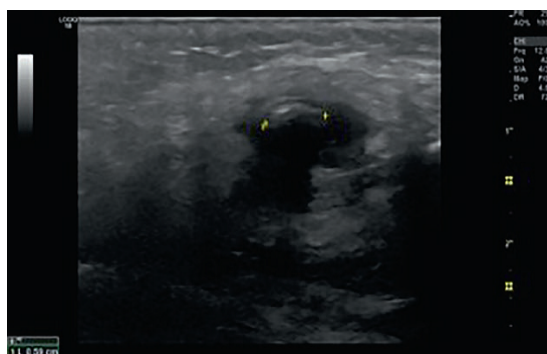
Ultrasound image of sialolithiasis of submandibular gland.
